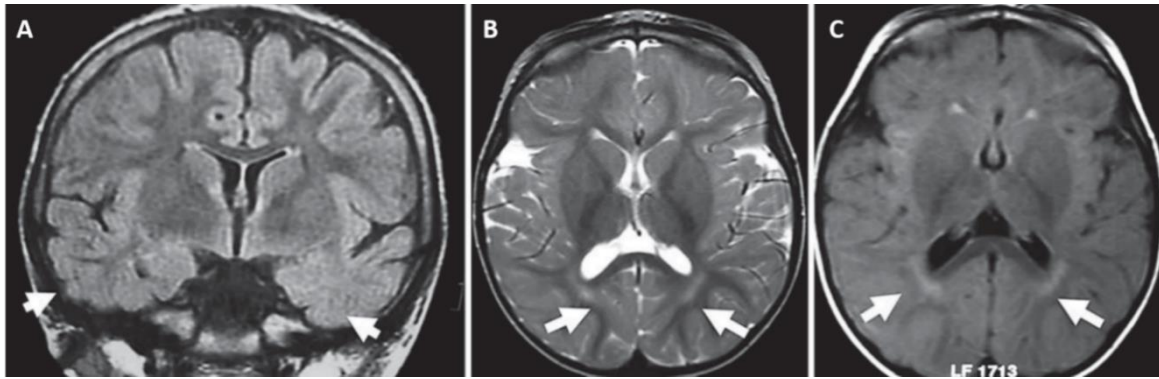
Brain MRI findings for patients with *CDKL5* point mutations. A- Nonspecific hyperintensities in both temporal lobes (T2 FLAIR coronal section) in a 12-year-old *CDKL5* mutation patient. B- Nonspecific periventricular hyperintensities (T2 axial section) in a 3-year-old *CDKL5* mutation patient. C- Nonspecific periventricular hyperintensities (T2 FLAIR axial section) in a 9-month-old *CDKL5* mutation patient. Arrows show the location of the main abnormalities in each figure (Bahi-Buisson & Bienvenu, 2012).
